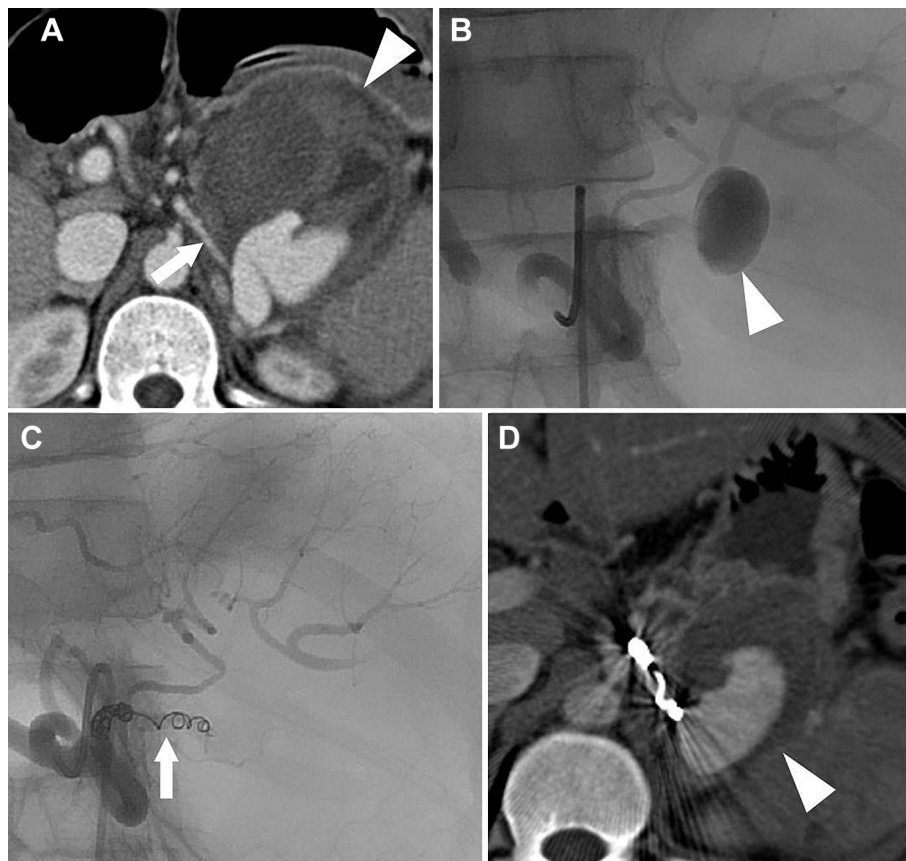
A 35-year old male with chronic pancreatitis presented with hematemesis. (A) Contrast-enhanced computed tomography (CT) and (B) celiac digital subtraction angiography shows the pseudoaneurysm (B, arrowhead) arising from distal splenic artery (A, arrow). (C) Distal access was not achieved and only the proximal splenic artery was coil-embolized (arrow). (D) Contrast-enhanced CT 1 month later shows reperfusion of the pseudoaneurysm (arrowhead).
